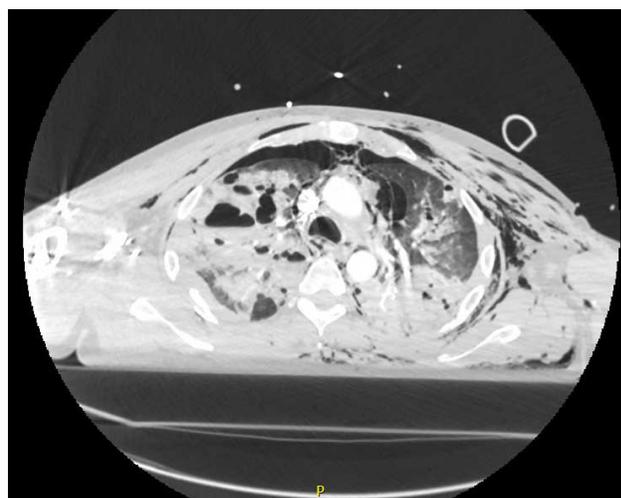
A chest computed tomography scan of the injuries.
